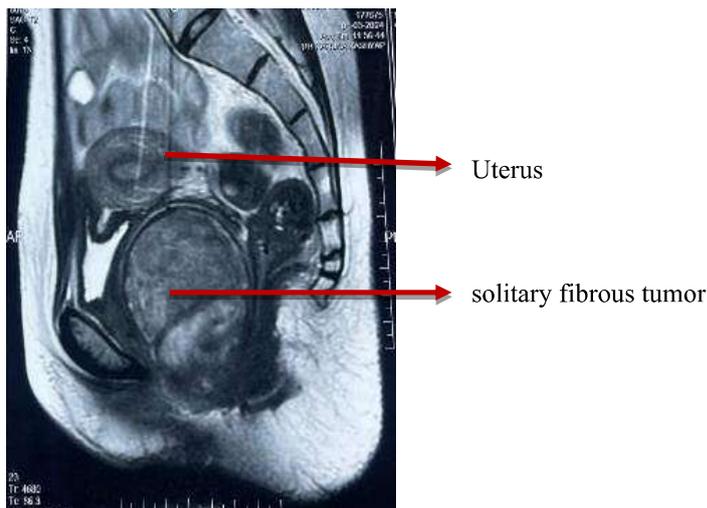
MRI (T2 weighted image): Heterogenous iso to hyperintense bilobed lesion involving right lateral vaginal wall – possibly suggestive of large vaginal leiomyoma.
